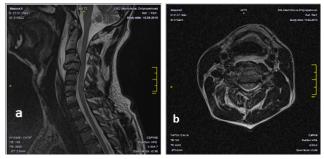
Magnetic resonance imaging. A dislocation fracture of C3–C4 can be observed. (a) Sagittal view. (b) Axial view.
